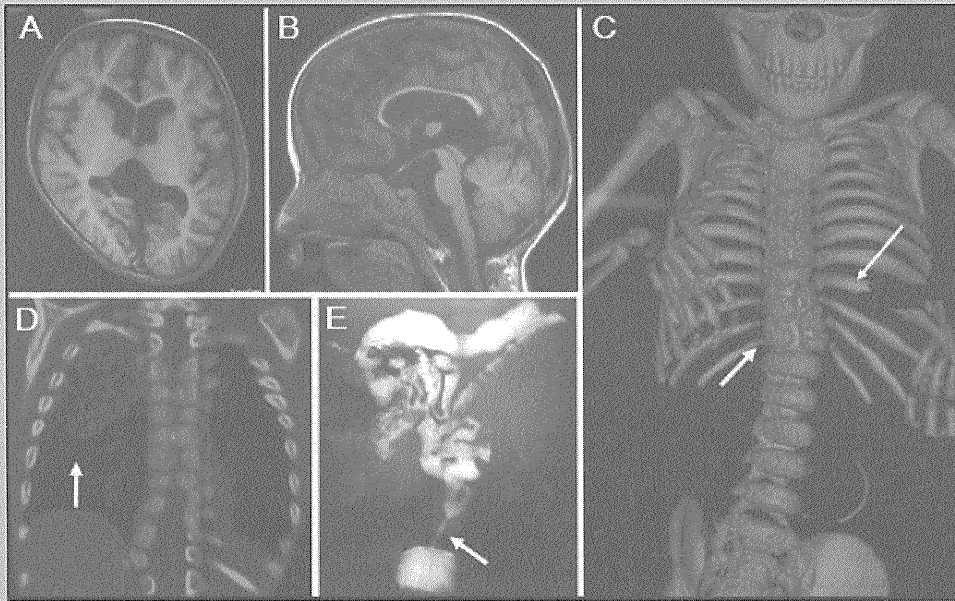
CT and MRI findings of the patient. A,B: Brain MRI [T1-weighted image] at 3 years of age showed decreased volume of the cortex in the frontal and parietal lobes, the presence of a subdural cyst in the corpora quadrigemina, and dilatation of the lateral and fourth ventricle. C: A bone survey performed using 3D CT showed abnormal segmentation of the ninth rib and an imbalanced hemivertebrae in the two lowest thoracic vertebral bodies [shown with arrows]. D: CT of the chest showed CCAM (indicated by the arrow) in the right upper lobe. E: Barium enema showed a reduced caliber rectum (indicated by the arrow), suggesting that the patient had Hirschsprung disease.
